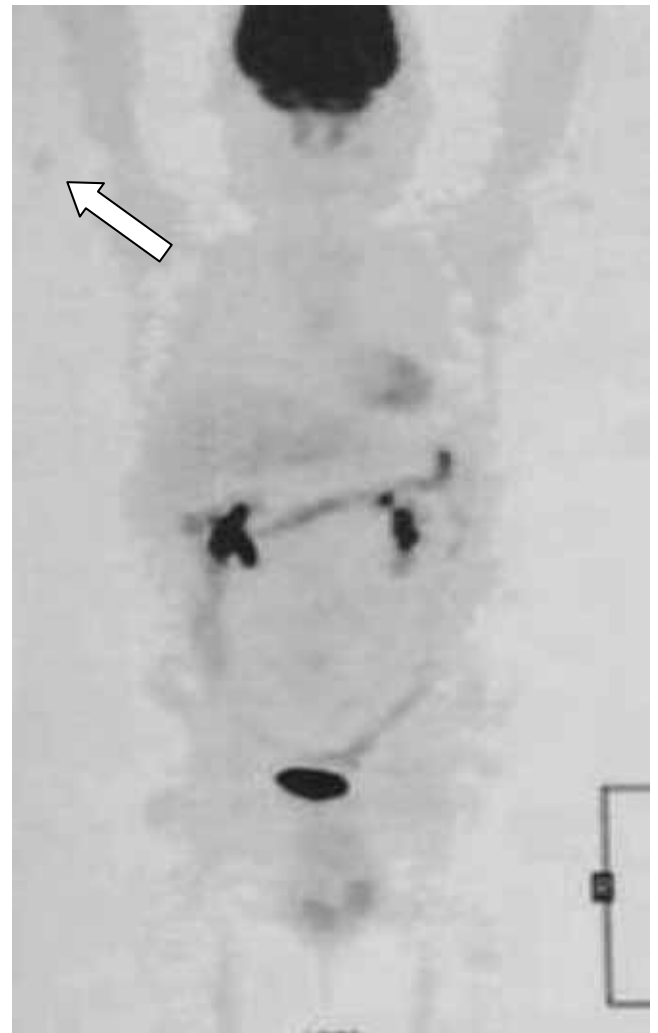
PET F-18-FDG coronal image shows abnormal increased uptake at the superior posterior aspect of the right arm. (Arrow)
